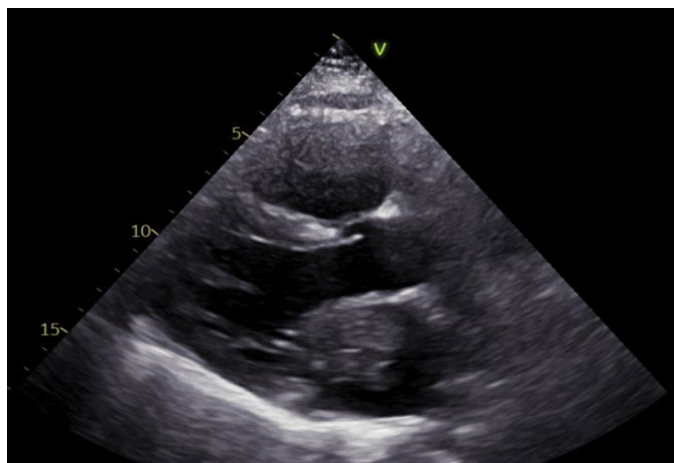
Large 6.2 cm × 3.5 cm left atrial mass noted on echocardiography on 11/5/22.
